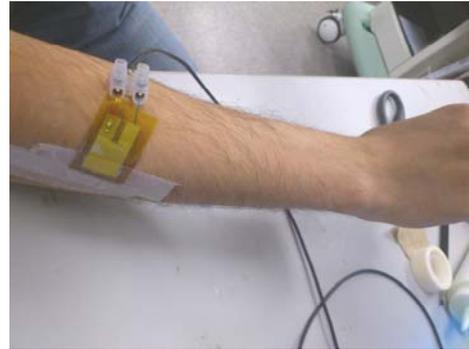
Wearable ultrasonic sensor attached onto a right forearm.
